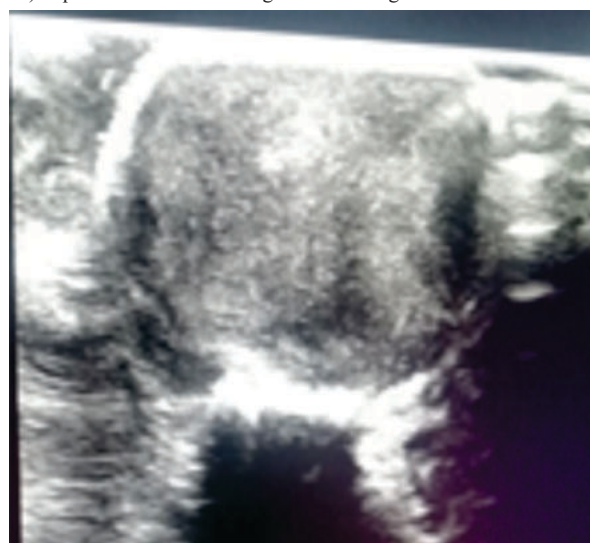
Greyscale Ultrasound Imaging Of Extra Nasal Mass
